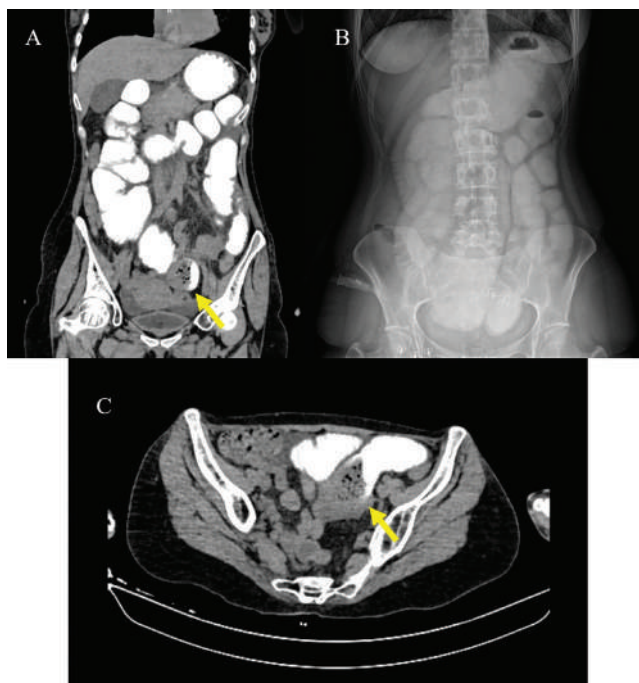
Preoperative imaging findings. (A) and (C) Coronal and axial CT images reveal a well-defined, mottled, gas-filled intraluminal mass within the small bowel (yellow arrows). Significant proximal bowel dilatation is present, consistent with a mechanical intestinal obstruction. (B) Upright abdominal X-ray reveals multiple dilated small bowel loops with a notable absence of distal gas, consistent with a mechanical obstruction.
